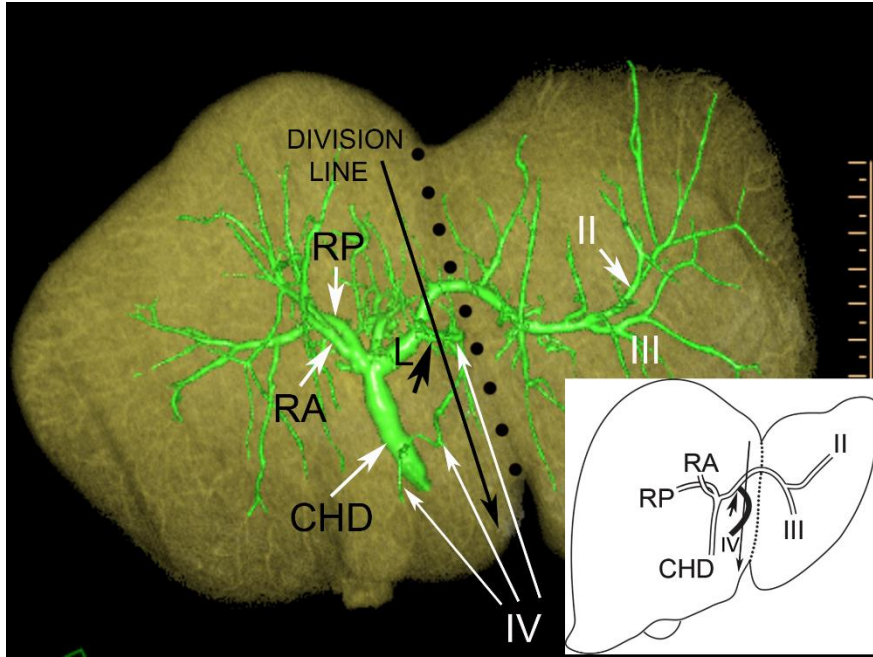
Dividing the liver 1 cm to the right of the FL may impair the bile drainage of segment IV in the remaining liver. Resection line is shown by the long black arrow, and FL is indicated by the black dotted line, while ducts draining segment IV are indicated by long white arrows. Short black arrow shows the joining of segment IV duct into the LHD. RA, right anterior hepatic duct; RP, right posterior hepatic duct; L, left hepatic duct; CHD, common hepatic duct. Roman numerals stand for the segmental ducts. (Source: author's own work. Co-workers: András Szuák, Tien Nguyen. CT pictures made by Ibolyka Dudás).
